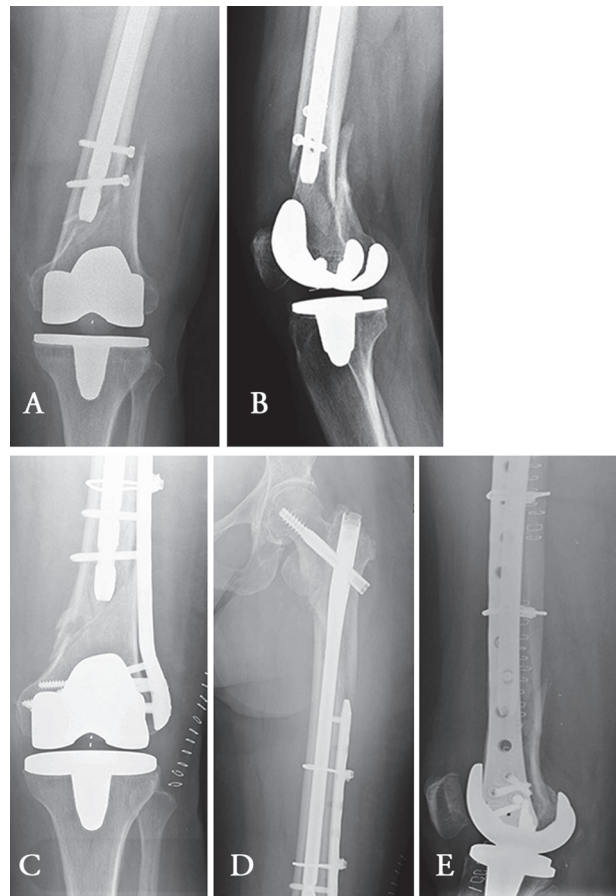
a, b) AP and lateral x-rays showing a distal femur periprosthetic knee fracture in a 80yrs old female patient treated 3 months before with a long cephalo-medullary nail for a subtrochanteric fracture. c, d, e) Radiographs obtained after open reduction internal locking plate fixation. A monocortical proximal screw, metal cerclages locked on the plate and bicortical screws inserted through the locking nail holes were all used to obtain stable fixation
